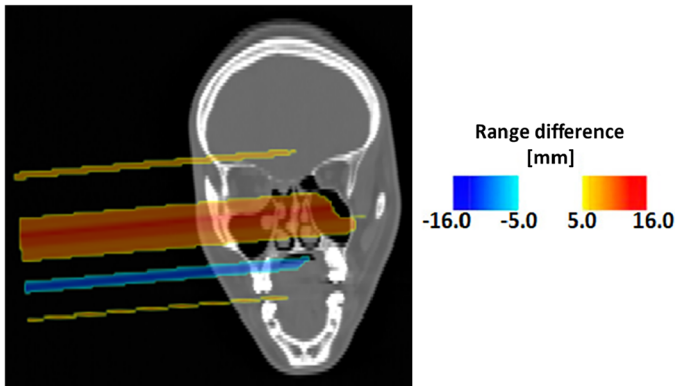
Color map referring to a patient treated with protons at CNAO and monitored with the INSIDE in-beam PET showing a morphological variation during the course of the therapy. The map is overlaid on the planning CT and the LUT of the range difference is shown on the right
